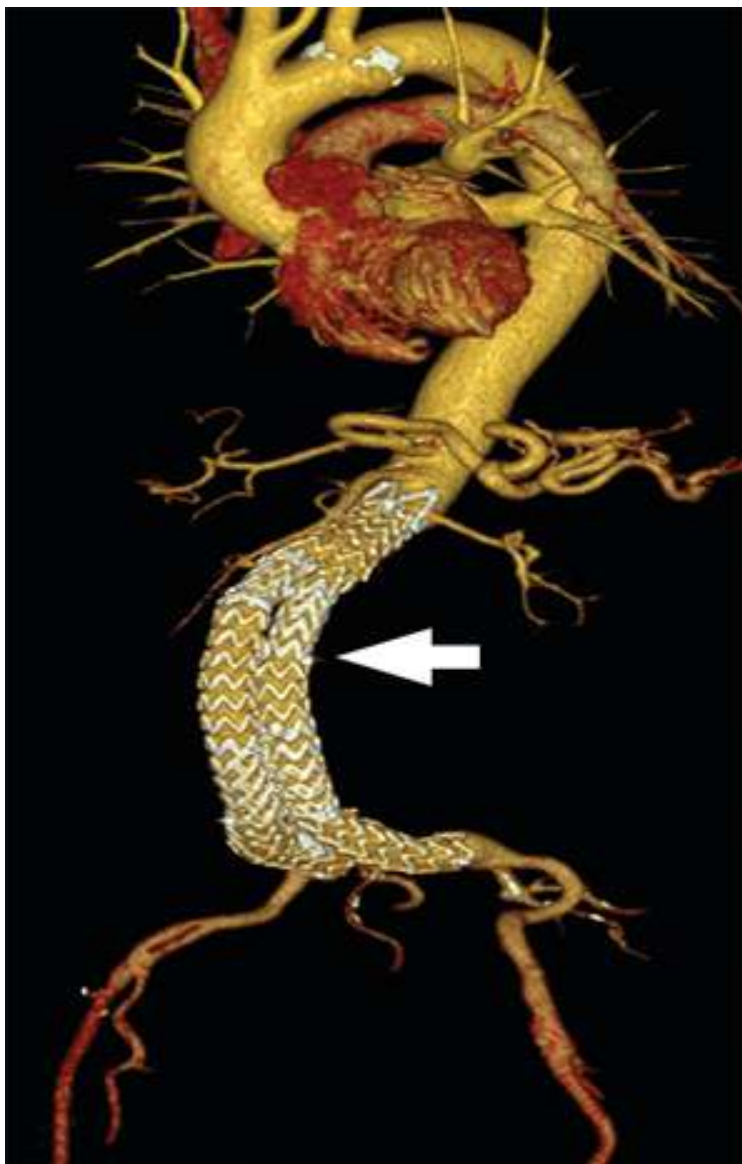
76-year-old man having CT angiography of the aorta following endovascular treatment of an infrarenal aneurysm.
